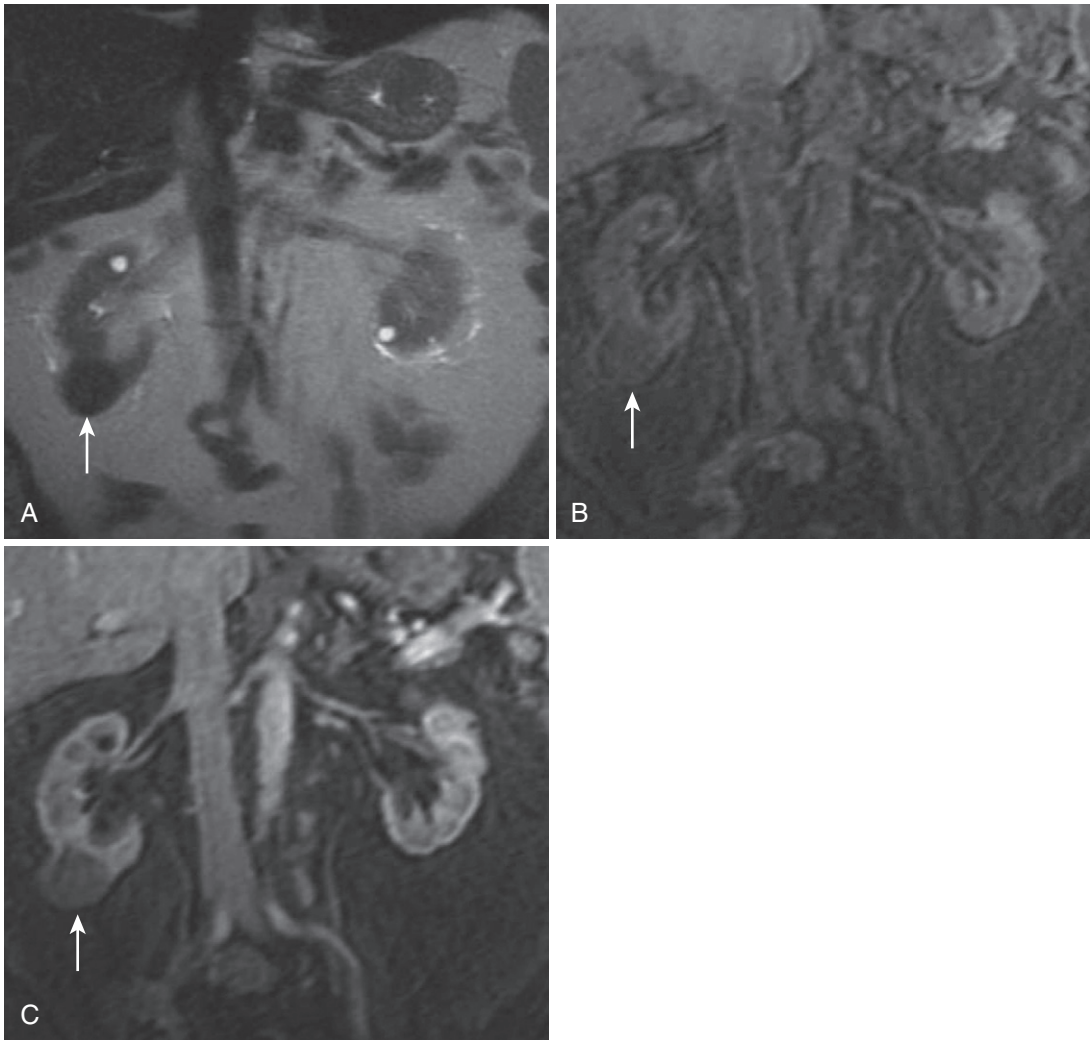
Papillary RCC with T2 hypointensity. A markedly hypointense lesion (*arrow*) arises from the lower pole of the right kidney on the coronal T2-weighted image (A), which appears to mildly enhance based on mild relative hyperintensity after gadolinium administration from the precontrast (B) to the postcontrast (C) images—typical of papillary RCC.
